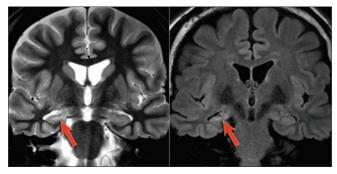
T2-weighted and fluid attenuated inversion recovery images are the most sensitive for detecting mesial temporal sclerosis. The high signal in the hippocampus reflects gliosis
